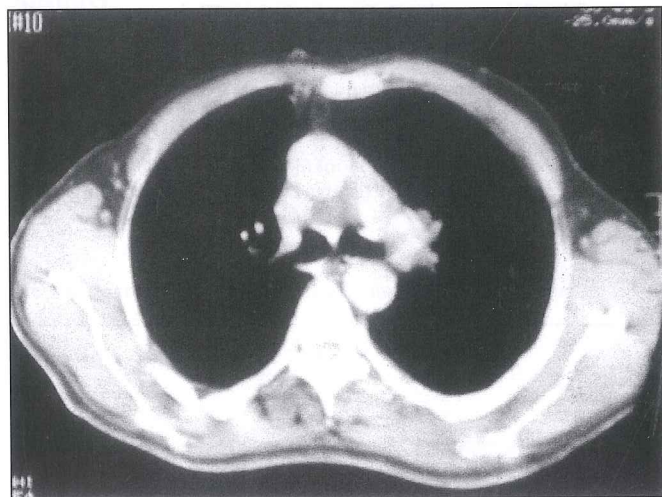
Computed tomography obtained three months after discharge showing remodeled airway from carina to bronchus intermedius. A minimal narrowing caused no morbidity and disappeared after 6 months.
